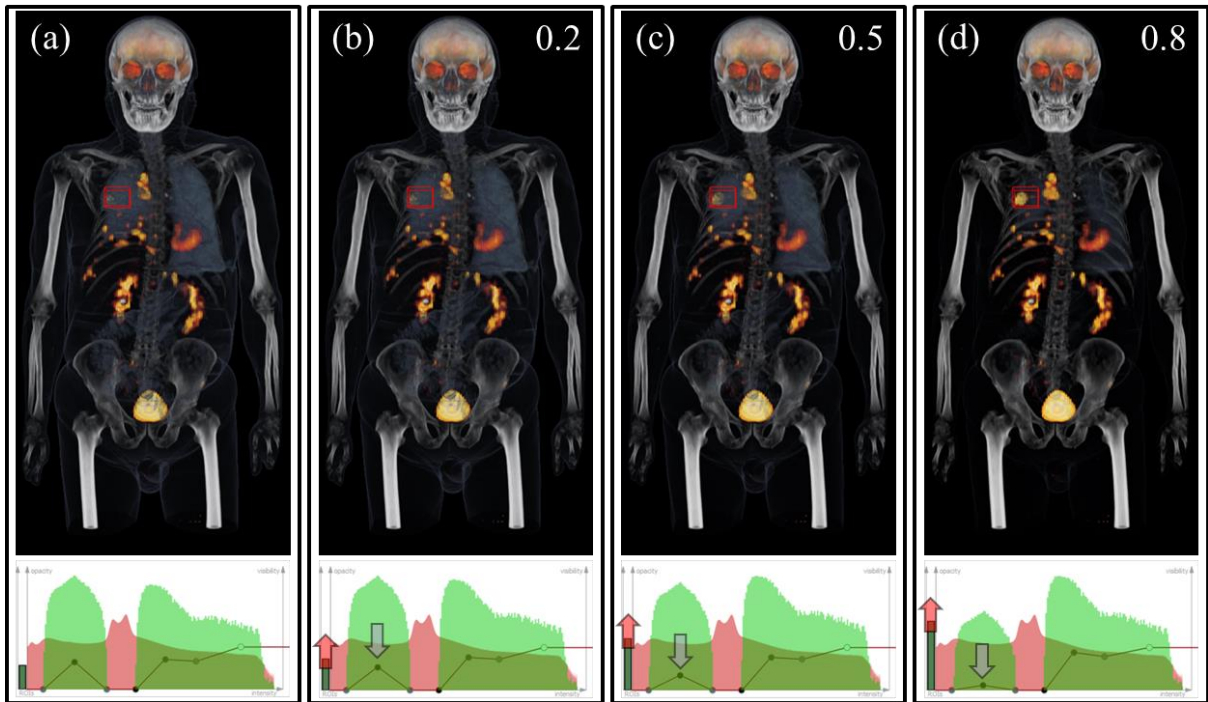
Automated CT transfer function according to varying optimisation constraint of ROI's visibility tolerance from low (0.2) to high (0.8).
